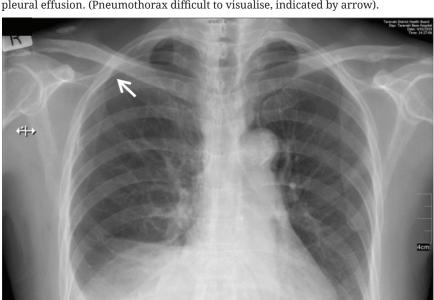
Post-operative day 1 chest x-ray showing right-sided pneumothorax and pleural effusion. (Pneumothorax difficult to visualise, indicated by arrow).
